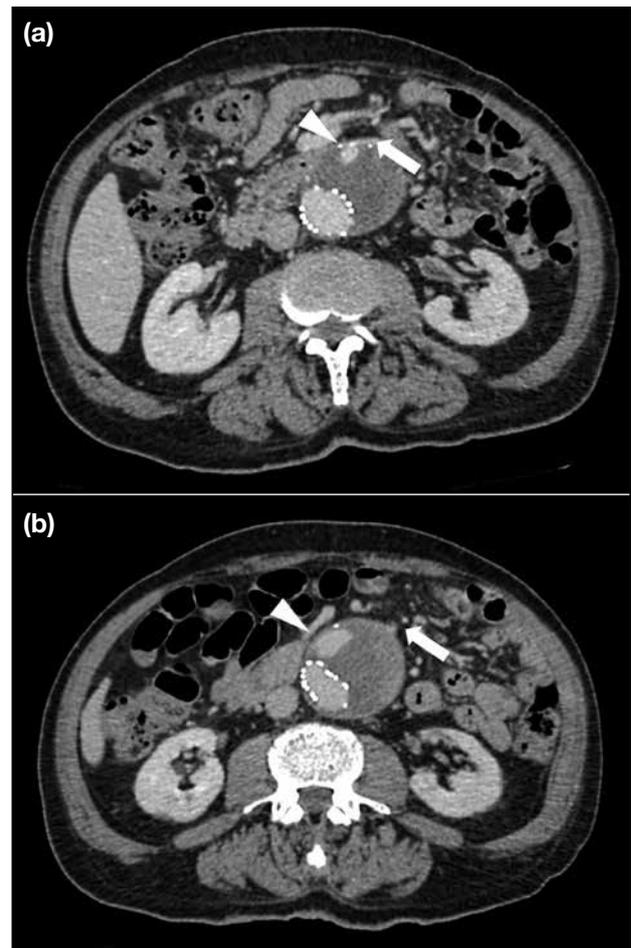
Type II endoleak supplied by the inferior mesenteric artery. (a) and (b) show contrast computed tomography in arterial phase at two levels, demonstrating the endoleak (arrowheads) from the inferior mesenteric artery (arrows).
